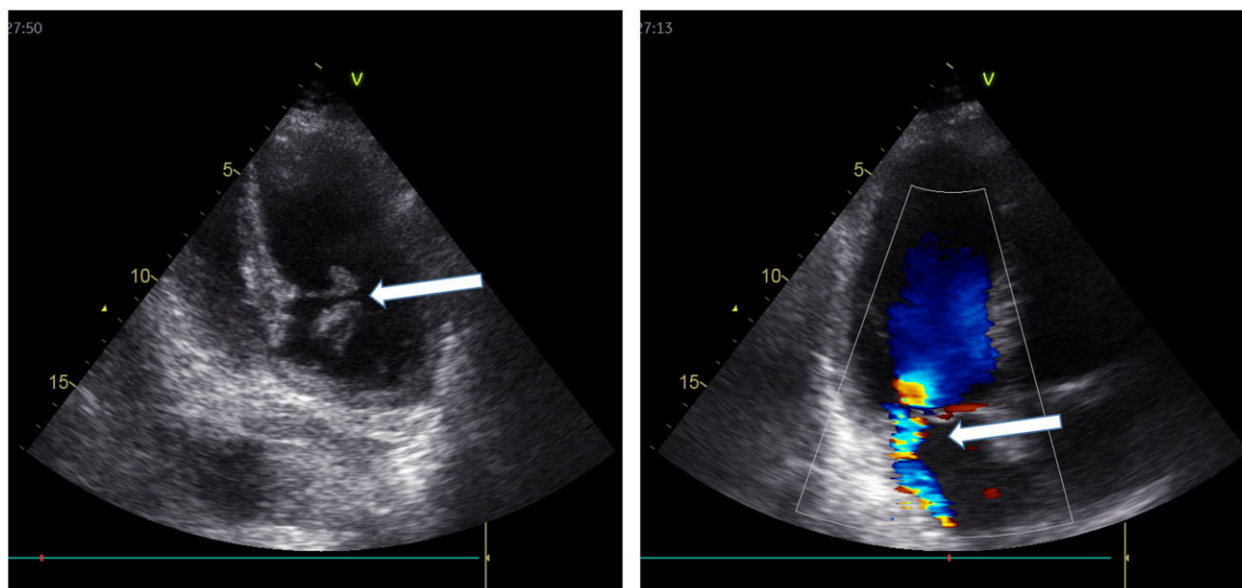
Echocardiography can quickly reveal complications in ACS. Large papillary muscle rupture after acute myocardial syndrome in a 69 years old male. Left panel is a modified apical four-chamber view and the ruptured papillary muscles are easily seen (white arrow). Right panel reveals the associated severe mitral regurgitation (white arrow).
